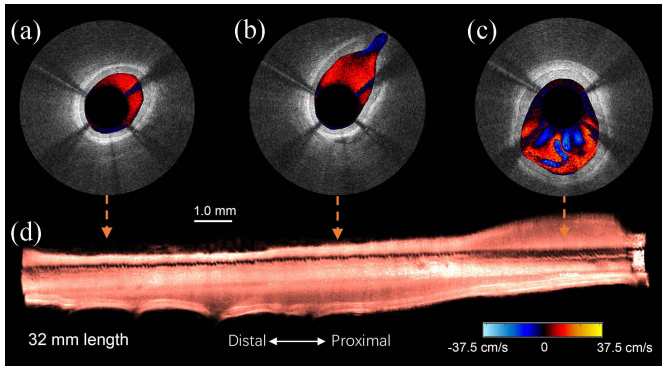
Doppler images overlaid with structural images acquired at different locations of the coronary artery. (a) overlaid Doppler OCT images acquired at distal end. (b) overlaid Doppler-OCT image acquired near a sidebranch. (c) overlaid Doppler-OCT image acquired at proximal end. (d) 3D reconstruction of the coronary using the OCT structural images. The overlaid Doppler-OCT images and the 3D reconstruction were reconstructed using single dataset acquired at 40 mm/s pullback speed and 600 frames/s imaging speed. The color bar indicates the velocity measured along the OCT beam.
